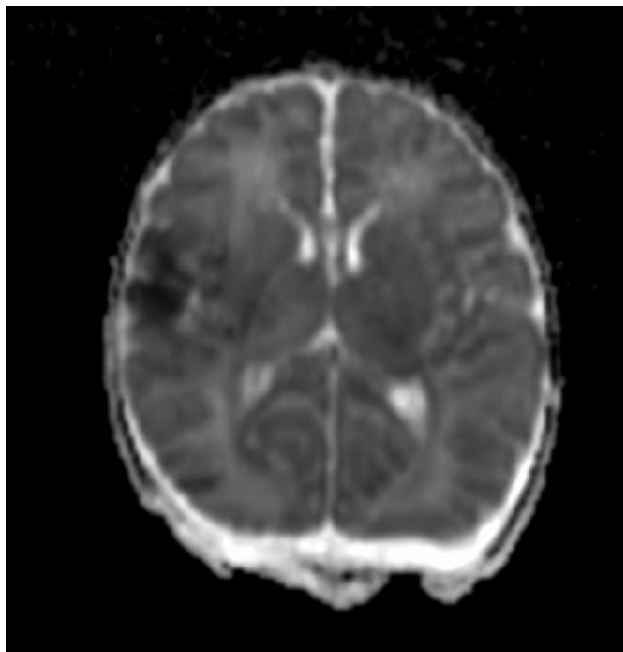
MRI OF NORMAL BRAIN.
